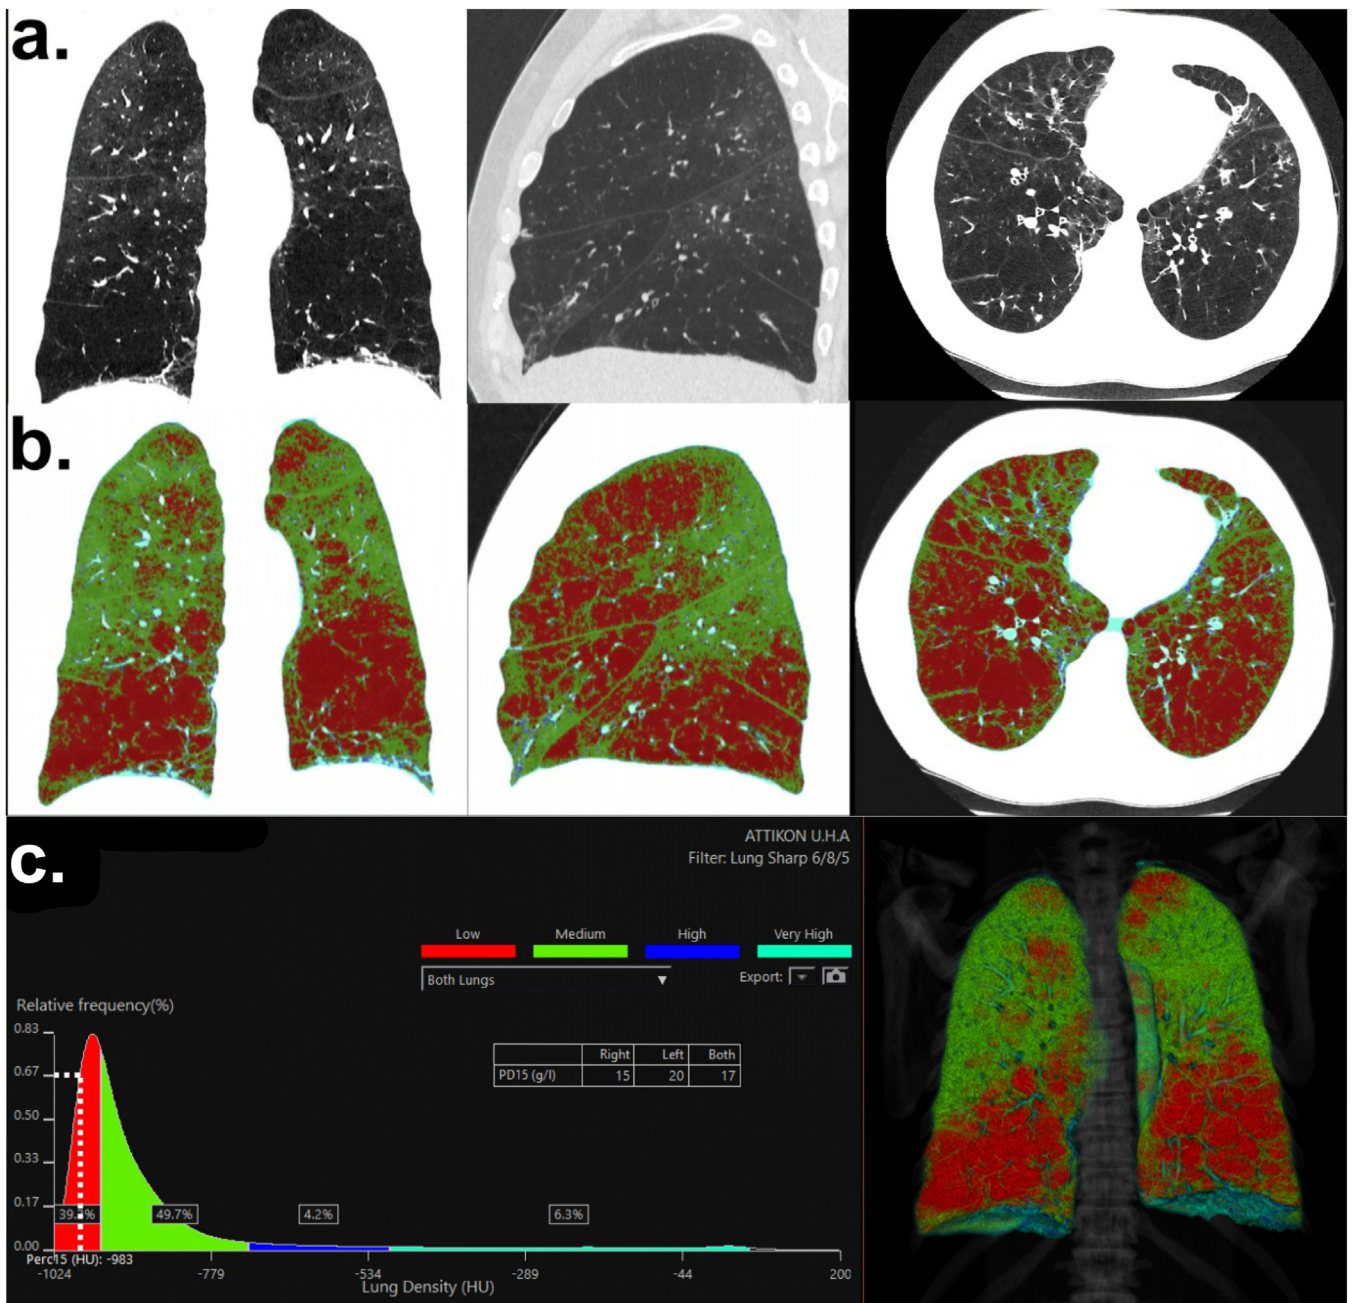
a. High-resolution chest computed tomography of the proband. Normal lung parenchyma distortion due to emphysema. Frontal, sagittal and axial views (from left to right), b: Color-coded visual map on lung density analysis to assess lung emphysema. Red-colored pixels represent attenuation lower than <-950 HU, c: Lung density distribution graph. PD15 = -983 HU shows an estimated pulmonary density of 17 g/L (for both lungs). The percentage of emphysema (areas of low-attenuation) was estimated $\sim 44,2\%$ for both lungs.
